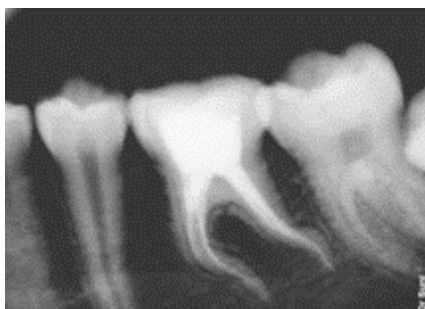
Immediate postoperative radiograph of 36.
